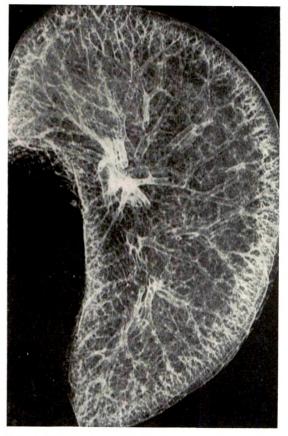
Roentgenogram of a thin slice of lung after injection of the pulmonary arteries. Note the abrupt change in the number of visible small vessels, between "medulla" and "cortex." Actually, there are many more "respiratory" capillaries in the medulla, but these are too small to be seen. (Courtesy of Dr. Charles B. Oderr, New Orleans, La.)
